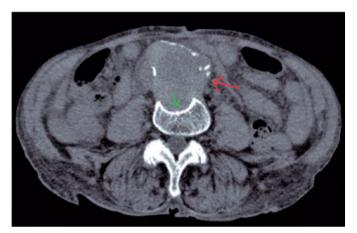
Axial computed tomography image of total abdomen with no contrast enhancement shows aortoiliac aneurysm with peripheral calcifications (red arrow), causing erosion of the anterior aspect of L4 vertebral body (green arrow)
